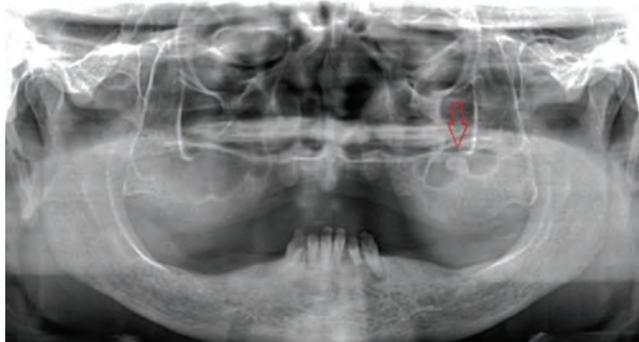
Panoramic radiograph in centric occlusion, occlusal plane parallel to the ground, and median line upright to the occlusal plane, where the pedunculated image is observed inside the left maxillary sinus.
